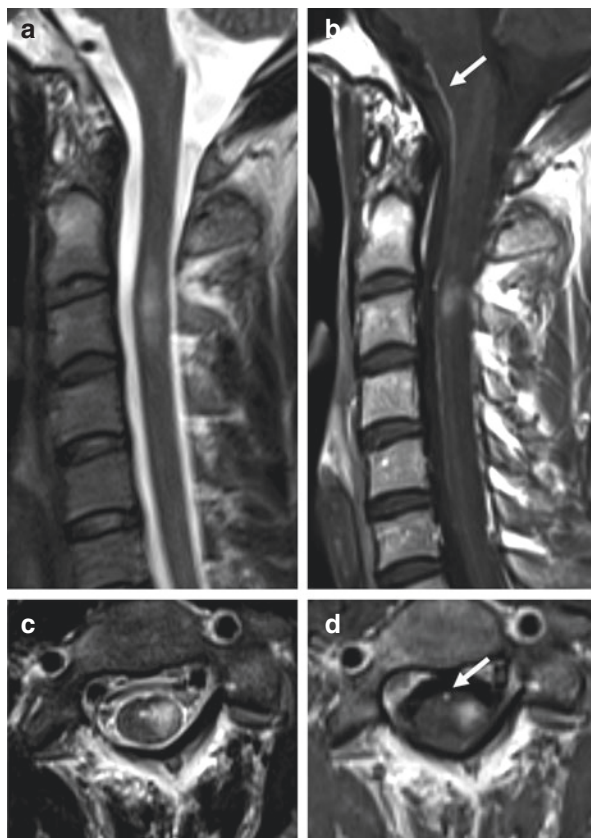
Multiple sclerosis (MS). Spinal MRI of a 23-year-old male presenting with subacute onset of right-sided hypaesthesia of the trunk. The patient was subsequently diagnosed with a relapsing–remitting MS. (a, b) Sagittal and (c, d) axial T2- and T1-weighted images show a monosegmental laterally located myelitis. (b, d) Gadolinium enhancement is shown. *Arrows* indicate the anterior spinal artery (Images courtesy of Dr. Peter Raab, Neuroradiology, Hannover Medical School)
